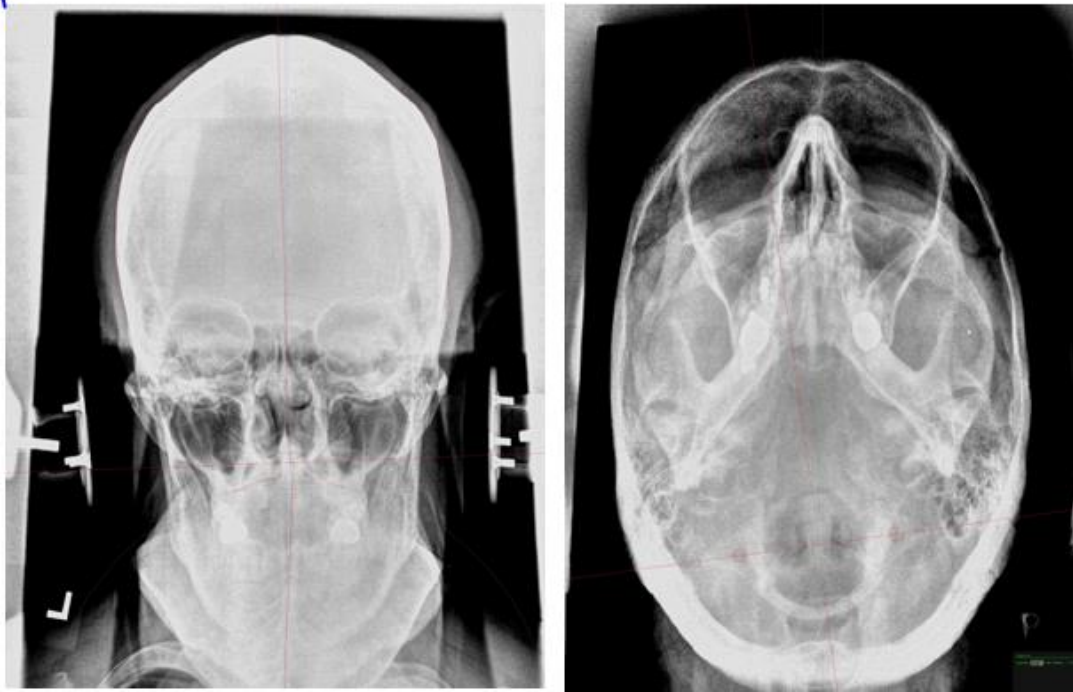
Pre-treatment nasium (left) and vertex (right) NUCCA radiographic analysis
